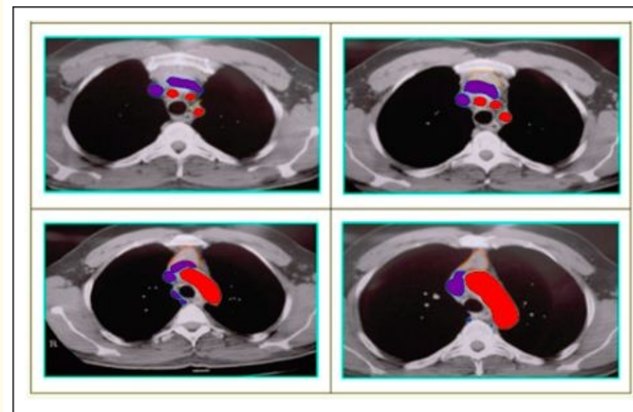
Computed tomography [CT] of the chest in modified mediastinal window.
